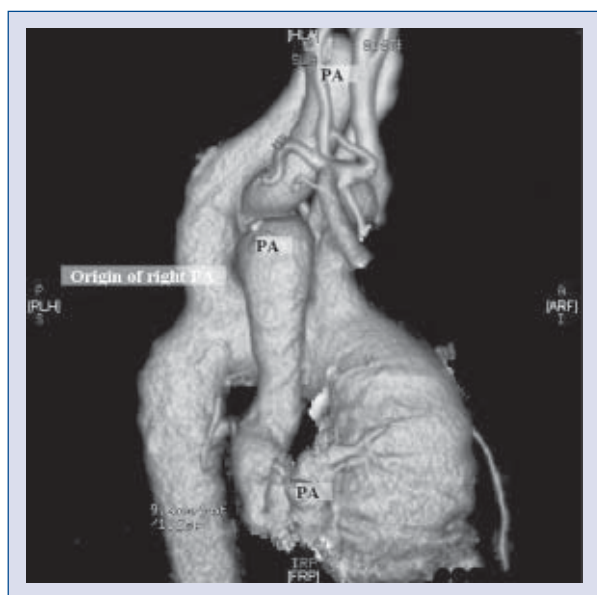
Axial computed tomography image showing right pulmonary artery (PA) arising from the arcus aorta.
